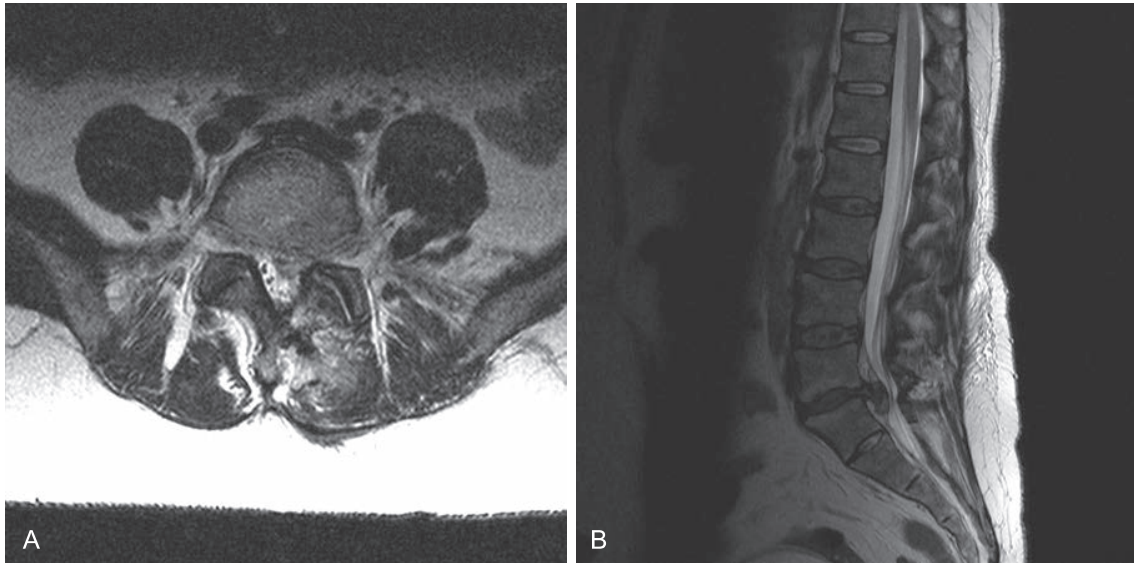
A, Axial MR image of S1 lumbar disc herniation. B, Sagittal MR image of S1 lumbar disc herniation.
